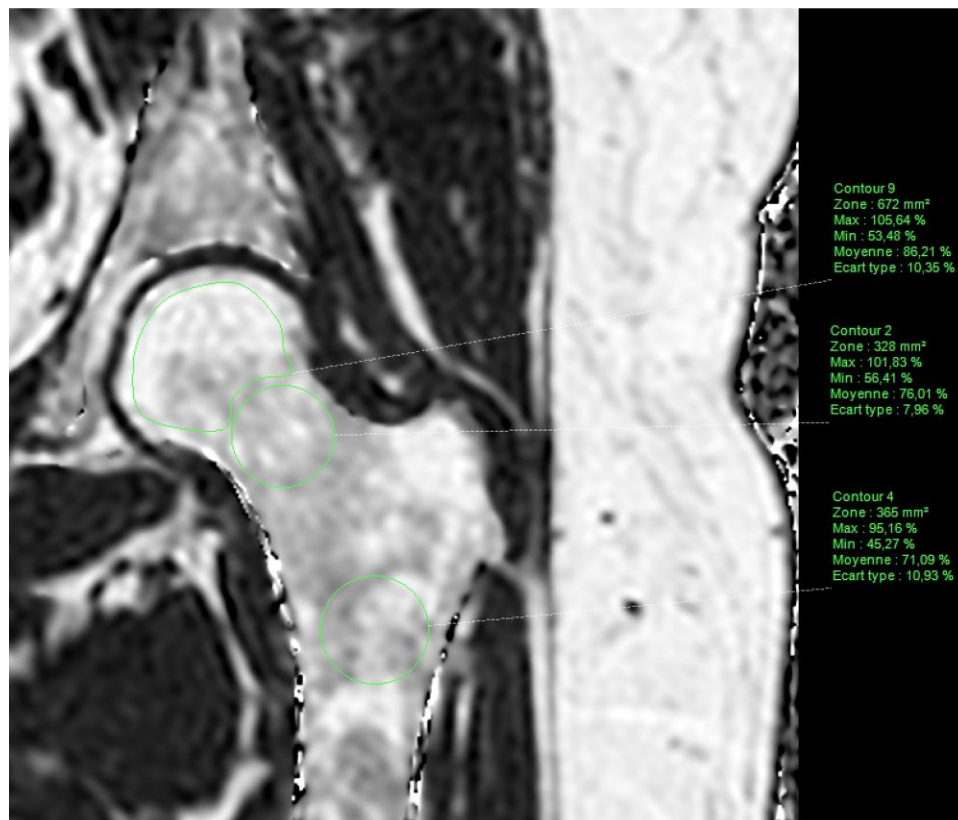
Imaging-based PDFF map of the hip PDFF map of the left (non-dominant) hip computed from a T1-weighted multi-echo gradient echo sequence (mDixon-Quant) acquired in a coronal oblique plane (along the femoral neck axis), from a 55-year old case. Manually segmented ROI was placed in the femoral head, femoral neck, and femoral diaphysis avoiding the cortical bone.
